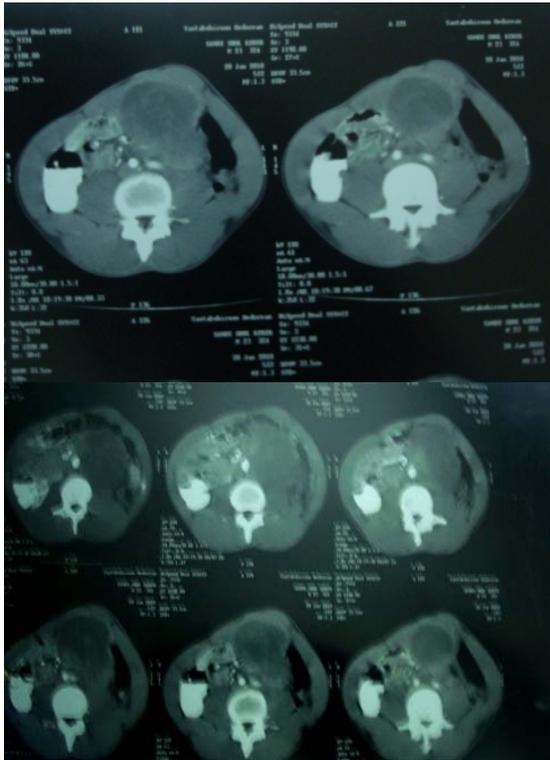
Computed tomography scan showing a mass in the left Para-aortic area encasing the left renal pelvis and vessels with marked central necrosis.
